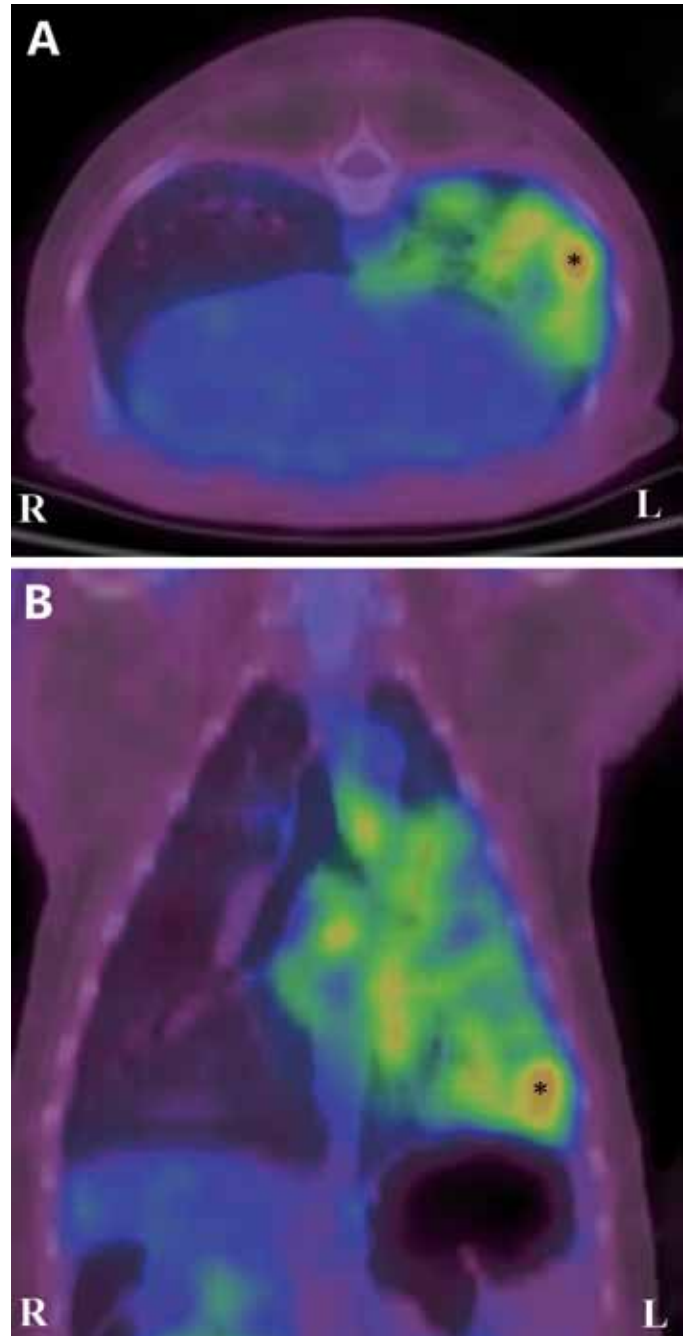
FDG-PET-CT images. The site of maximal FDG uptake value (asterisk) was the focus point for (A) axial and (B) coronal images. Increasing FDG uptake values are expressed as green, yellow, and orange colors.
